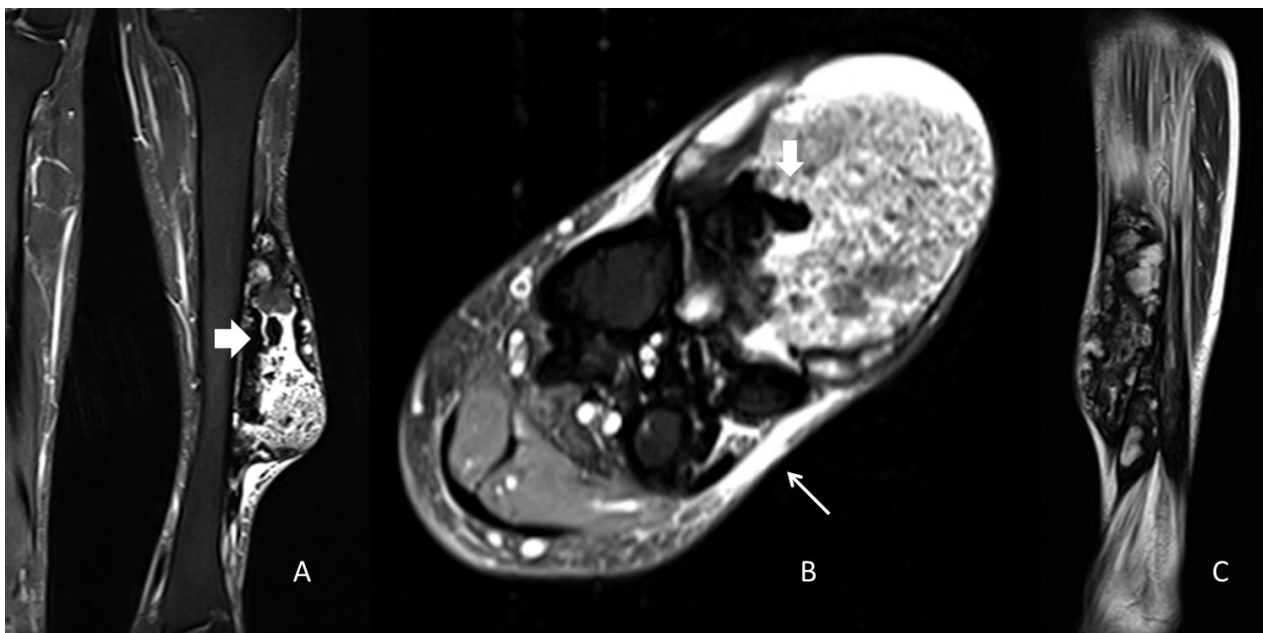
A 52-year-old male with chronic tophaceous gout. Short tau inversion recovery coronal (A) and axial (B) magnetic resonance sequences. T2-weighted sagittal image (C). The mass is heterogeneous with low intensity foci likely to represent the calcified components (thick arrow). Edema is seen along the adjacent margins of the mass (thin arrow). Technical parameters: Siemens AERA 1.5T, short tau inversion recovery coronal image (TR=3990; TE=60) and axial image (TR=3950; TE=12); T2-weighted sagittal image (TR=3230; TE=77).
